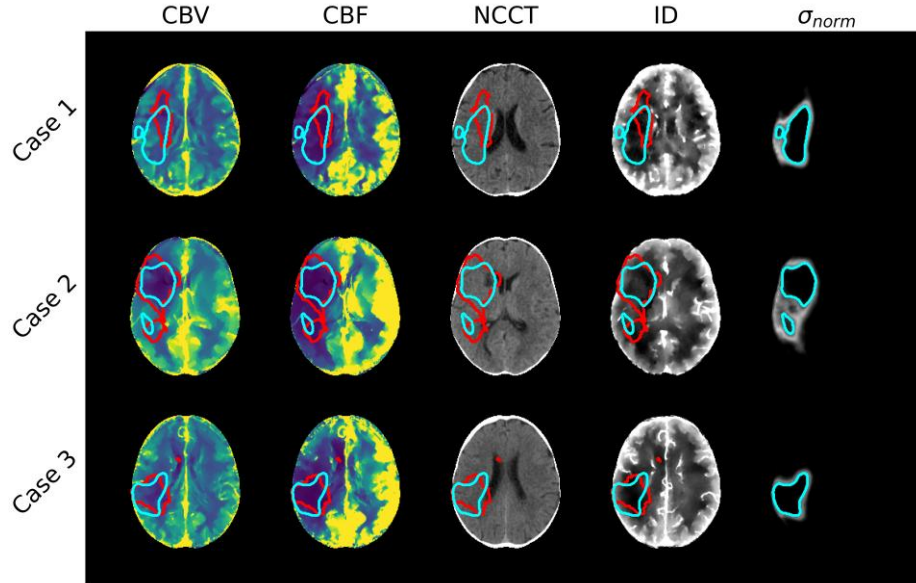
Cerebral blood volume (CBV), cerebral blood flow (CBF), non-contrast CT (NCCT), iodine density (ID), and uncertainty (σ_{norm} , visualization range 0 to 1) maps for three different subjects with the reference (red) and U-Net (cyan) segmentations overlaid. A large deviation from reference can be seen in case 1 where the segmented ischemic defect in the ID map more represents the CBF defect. Case 2 shows uncertainty of the network for the CBF defect. Case 3 shows a good match between CBV and ID defect and good correspondence between the prediction and reference.
